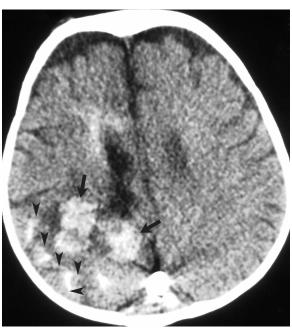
Unenhanced axial CT scan demonstrating diffuse subcortical calcification in the right parieto-occipital region (arrowheads), multiple cavernomas (black arrows) and dense glue material within the mural shunts of the SSS.
